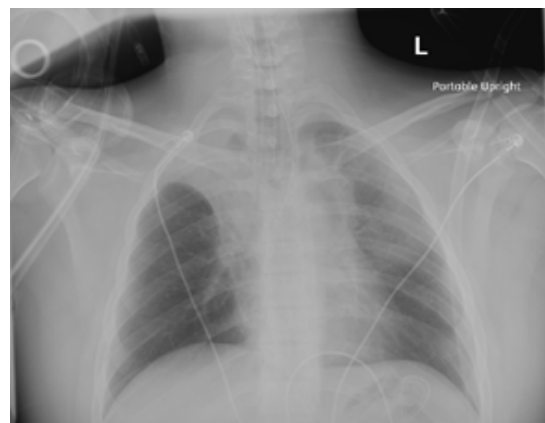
Anterior-posterior x-ray showing bilateral upper lobe collapse.
